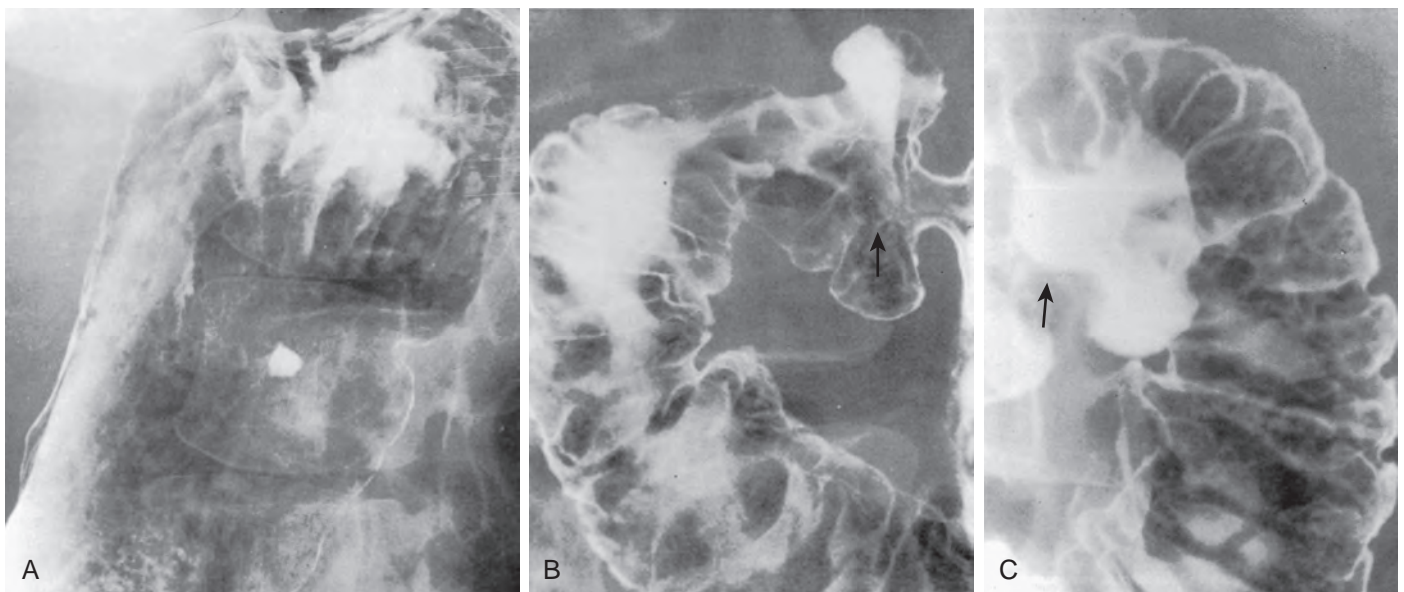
Depressed lesions. A. Dependent wall ulcer. Radiograph of the stomach in the right posterior oblique projection shows a high ulcer on the lesser curvature. B. Anterior wall ulcer. This spot image in the supine left posterior oblique projection shows a ring shadow (arrow) representing the nondependent ulcer crater etched in white on the anterior wall of a deformed duodenal bulb. C. With the patient in the prone position, the ring shadow fills with barium (arrow), indicating an anterior wall duodenal ulcer. (From Laufer I, Levine MS [eds]: *Double Contrast Gastrointestinal Radiology*, 2nd ed. Philadelphia, WB Saunders, 1992.)
